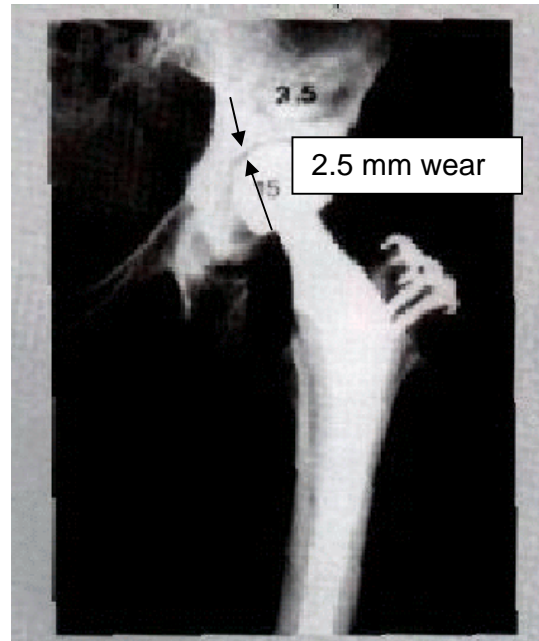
X-ray that shows 2.5 mm wear in cup as indicated by arrows as an eccentricity. No scale was shown in the reference but 30 mm femoral head serve as scale (Grobbelaar et al., 1999).
